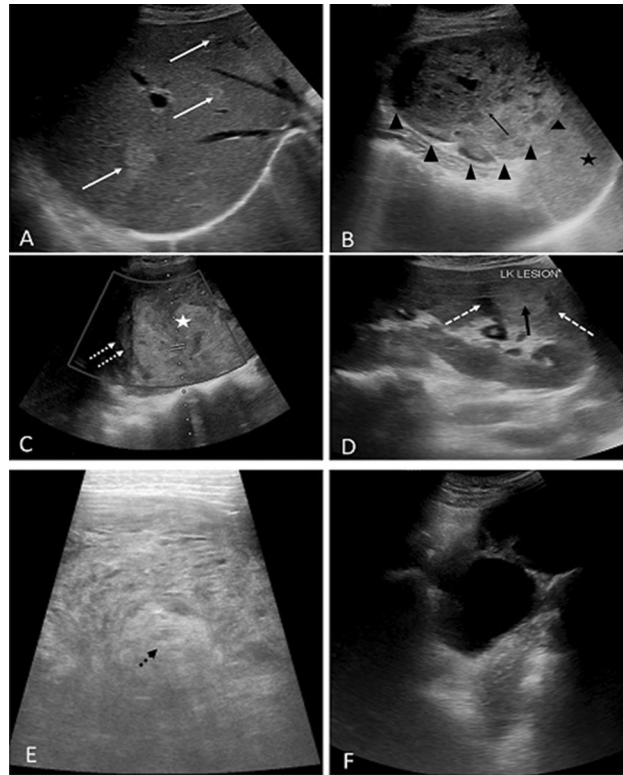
Ultrasound panel showing images acquired immediately after admission. (A) Liver scan showing multiple well-defined hyperechoic lesion of variable sizes (solid white arrows). (B) Heterogeneous hypoechoic lesion (outlined by black arrowheads) with internal cystic spaces in the spleen (black solid arrow), the normal spleen is seen at the lower part (black star). (C) Right kidney shows a large predominantly hyperechoic lesion (white star) with a heterogeneous hypoechoic collection adjacent to it (dashed white arrows). (D) Left kidney shows a hyperechoic lesion (small black solid arrow) with a hypoechoic rim around it (dashed white arrows). (E) Abdomen scan showing a hyperechoic lesion (small dashed black arrow) within the omentum which is draped all around it. (F) Complex cystic space-occupying lesion in the pelvis.
